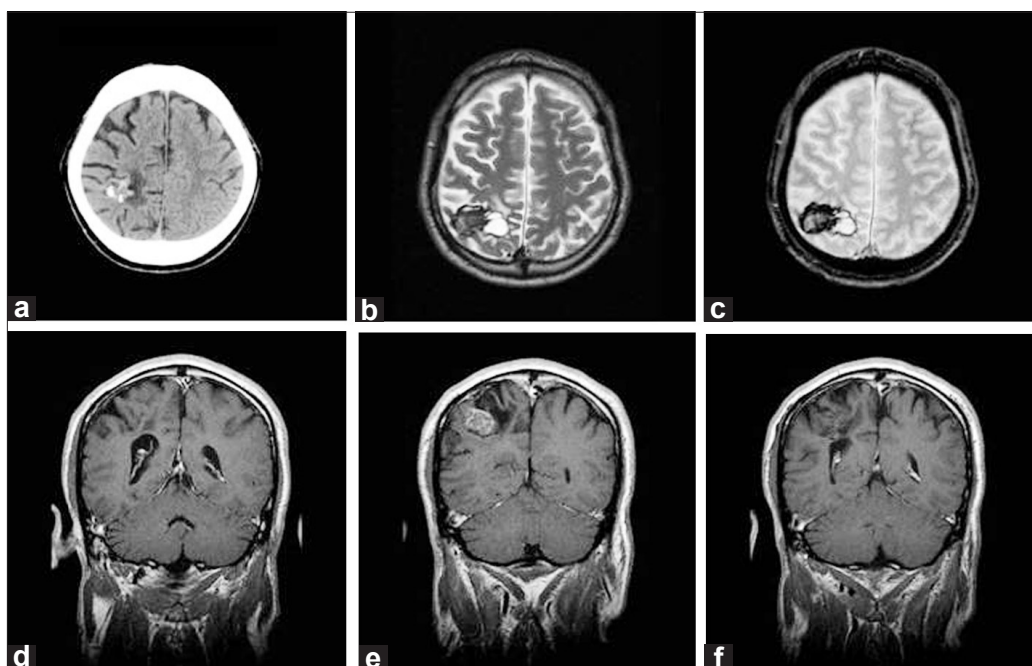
(a) Plain computed tomography (CT) of the head revealing a 40-mm-diameter tumor with calcification and cyst formation in the right parietal lobe. (b, c) Axial images are shown for magnetic resonance imaging (MRI). T₂ and T₂*-weighted imaging shows signal hyperintensity. T₂ and T₂*-weighted imaging reveals an area of marked hypointensity around the solid component, which may represent the calcification seen on CT or hemosiderin deposition due to an old hemorrhage. (d-f) Coronal images are shown for MRI. T₁ gadolinium enhancement shows a heterogeneous contrast effect. Note: The normal-appearing choroid plexus was placed within the lateral ventricle and continuity of the normal choroid plexus and the lesion was not confirmed
